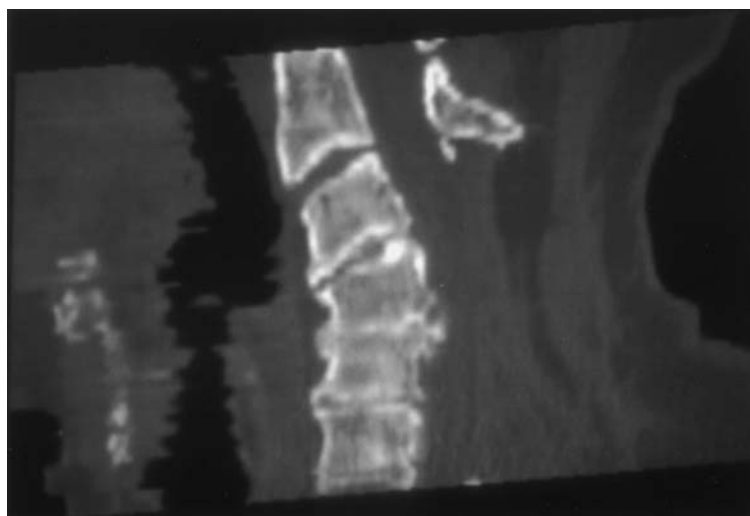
A sagittal CT scan reconstruction of the mid-cervical spine. The patient underwent a previous laminectomy and had transient improvement of his symptomatology, followed by progressive myelopathy. The kyphotic configuration of the spine and the anterior osteophyte have prevented adequate decompression of the spinal cord by the laminectomy.
